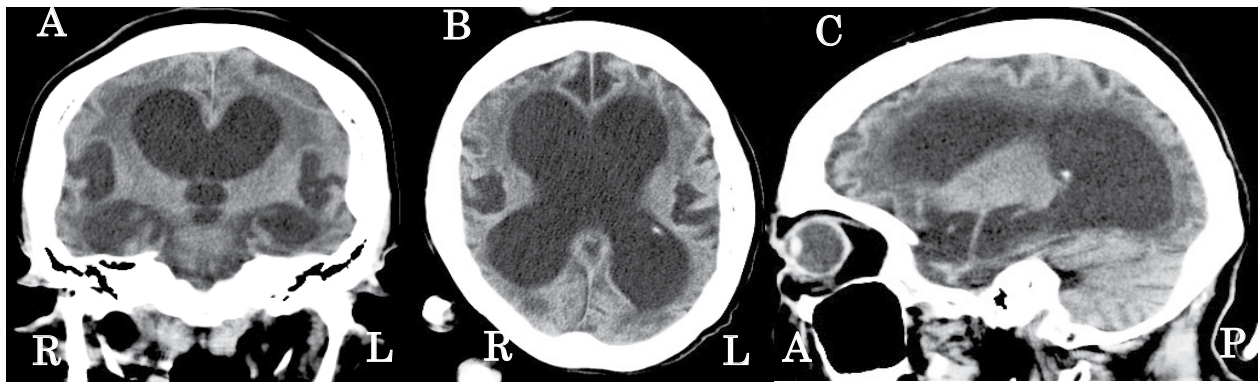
CT at 73 years old revealed extreme ventriculomegaly accompanied by DESH mimicking “possible iNPH”. (A) Coronal, (B) Axial, and (C) Sagittal sections.
